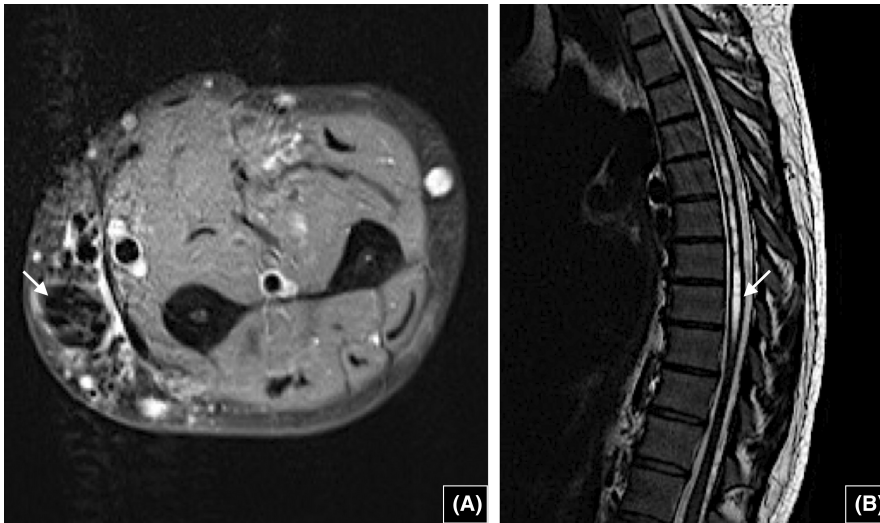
(A) Axial T1W gadolinium MRI of the forearm demonstrating the tumor. (B) Sagittal T2W MRI of the thoracic spine showing syringomyelic cavity at the level of Th3-Th11.
